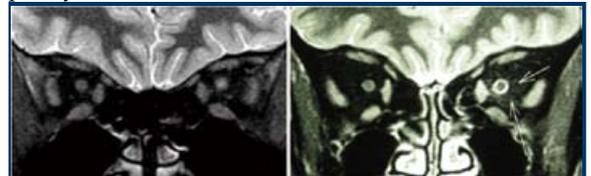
MRI (coronal short TI inversion recovery images) of the orbit in patients with left optic neuritis showing hyperintensity of the optic nerve (left), left optic perineuritis showing perineural hyperintensity around the left optic nerve (donut sign) with dirty fat sign depicted with arrows (right)²⁴
